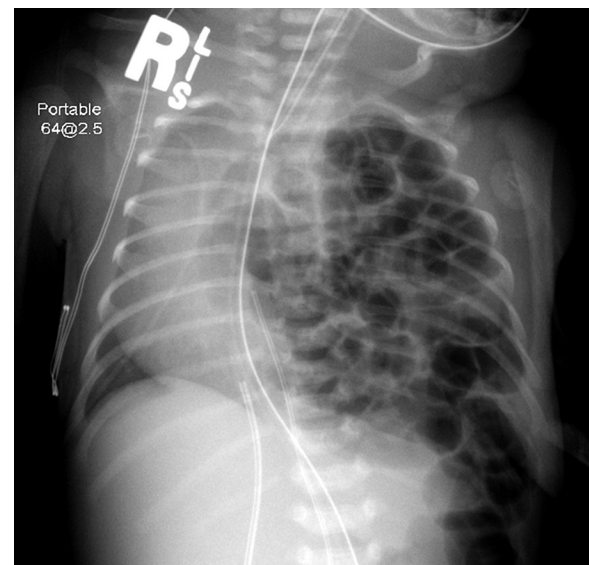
Radiograph of a left-sided congenital diaphragmatic hernia. Note the shift of the mediastinum to the right.
